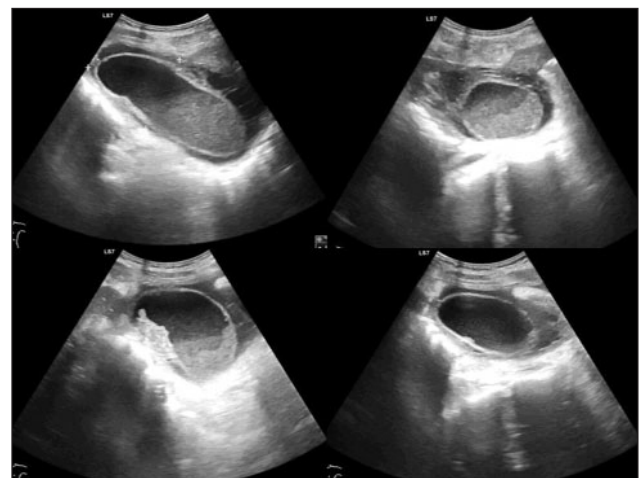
Ultrasound images of the gallbladder demonstrating signs consistent with acute gallbladder pathology. Findings include gallbladder distension, wall thickening, intraluminal sludge or debris, and pericholecystic fluid - features that may suggest acute cholecystitis or, in rare cases, G
